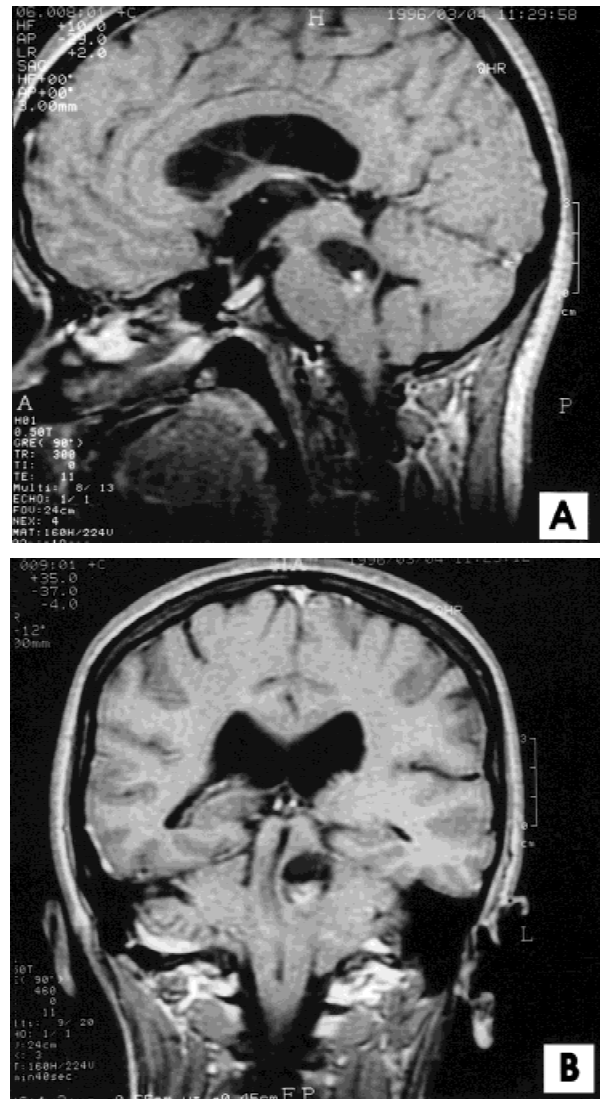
Preoperative magnetic resonance imaging. T1-weighted sagittal (A) and coronal (B) images, after administration of paramagnetic contrast (Gadolinium-GTDA): round cystic hypointense lesion filling the left pontomesencephalic region of the brain stem; an enhancing nodule is visible in the lower part of the cyst.
